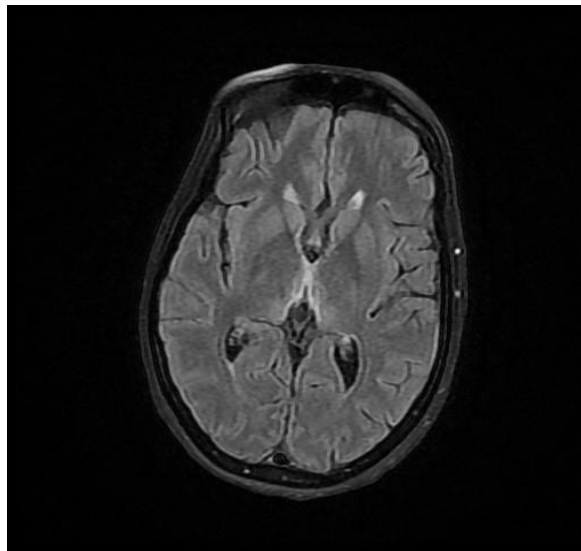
MRI slice showing FLAIR hyperintensity of the thalamus
